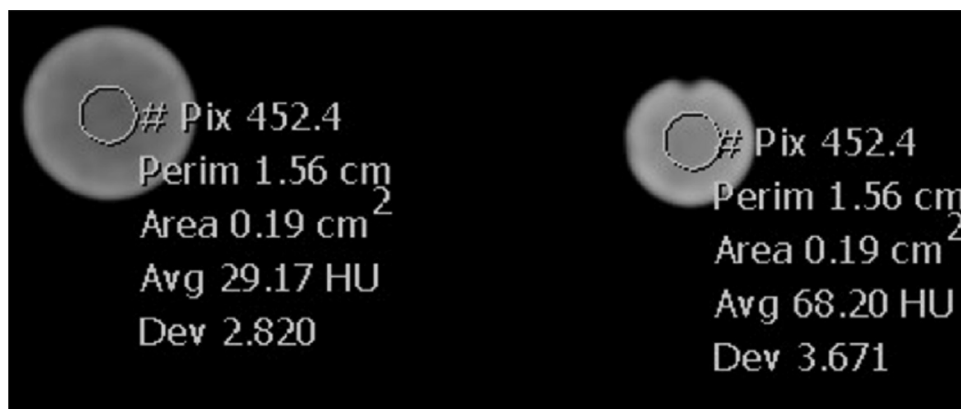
CT axial images of a syringe filled with saline (left) and a syringe filled with the serosanguinous output of surgical drainage (68 HU), which is over twice as dense as the saline (29 HU).
